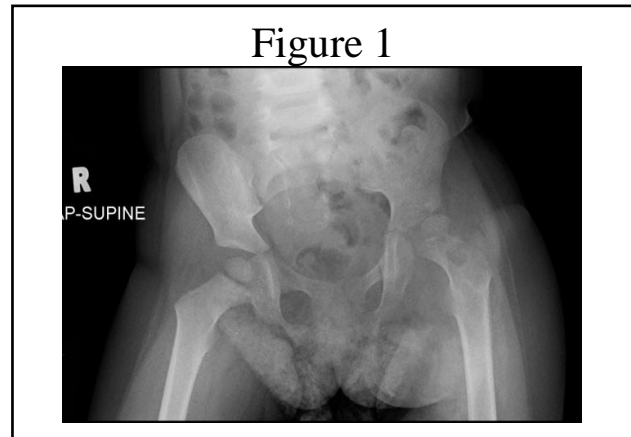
Xray prior 2<sup>nd</sup> washout
